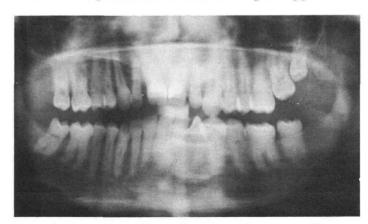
Panoramic radiograph of the patient at age 15.
